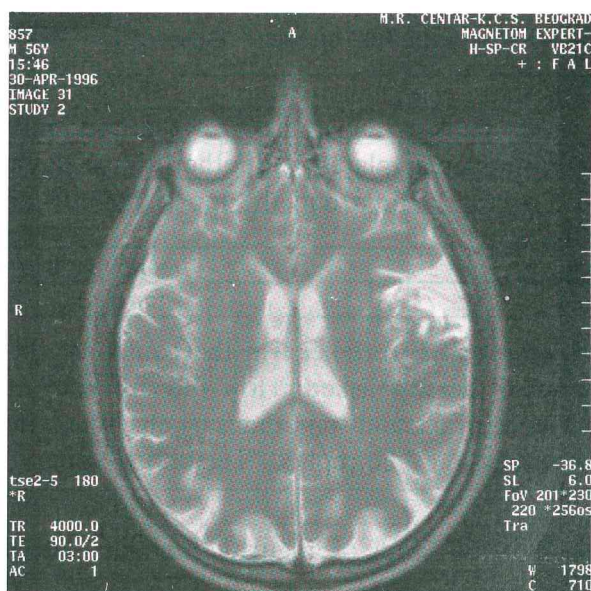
MR image evidenced hemorrhagic infarction in the temporo-parietal region of the left hemisphere
